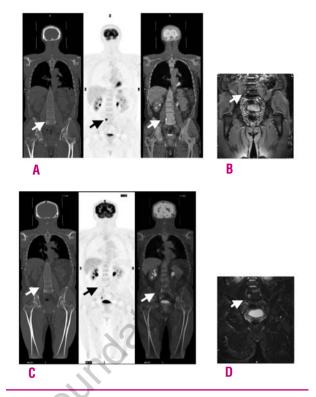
Images performed on a 49-year old male with a lombar plasmacytoma. Before treatment, plasmacytoma was detected by FDG PET/CT (A) and MRI (B). After external radiotherapy, FDG PET/CT (C) revealed no abnormal uptake. MRI (D) showed a persistent abnormal spine signal. Follow-up confirmed the absence of recurrence.
